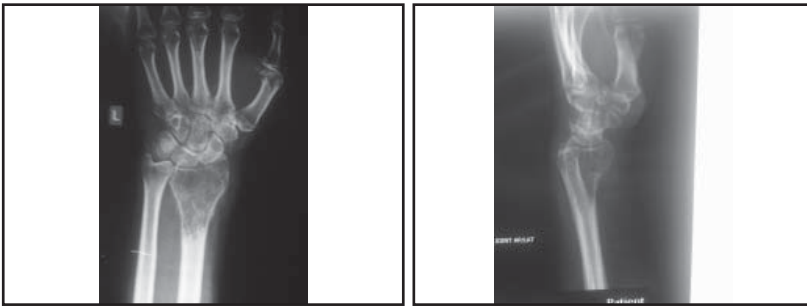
The radiograph of the same patient with its AP & lateral view
